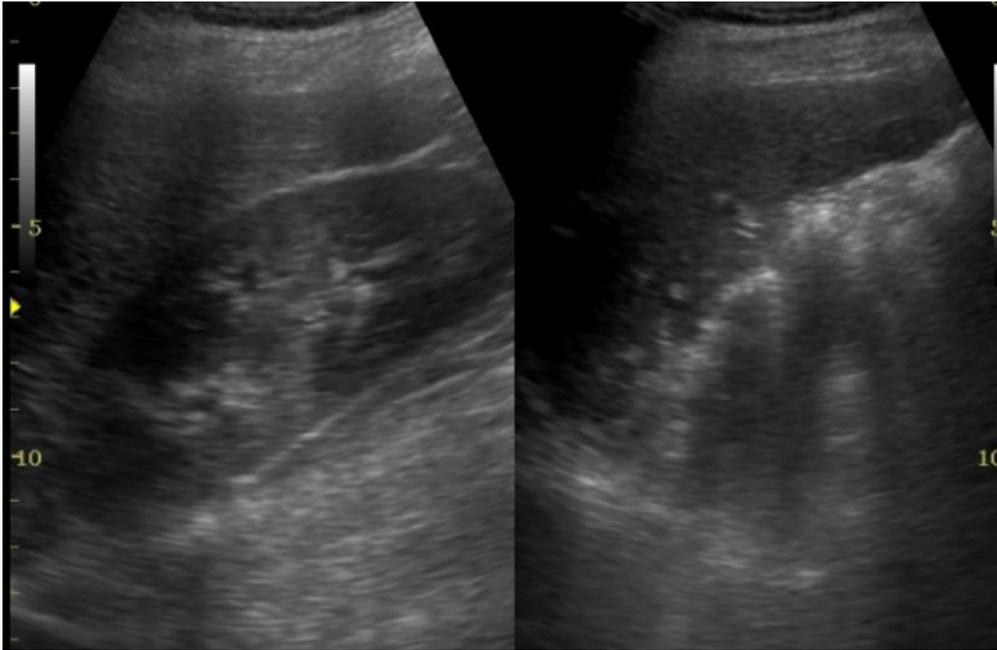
Ultrasound images showing Right kidney in right renal fossa and empty left renal fossa.
